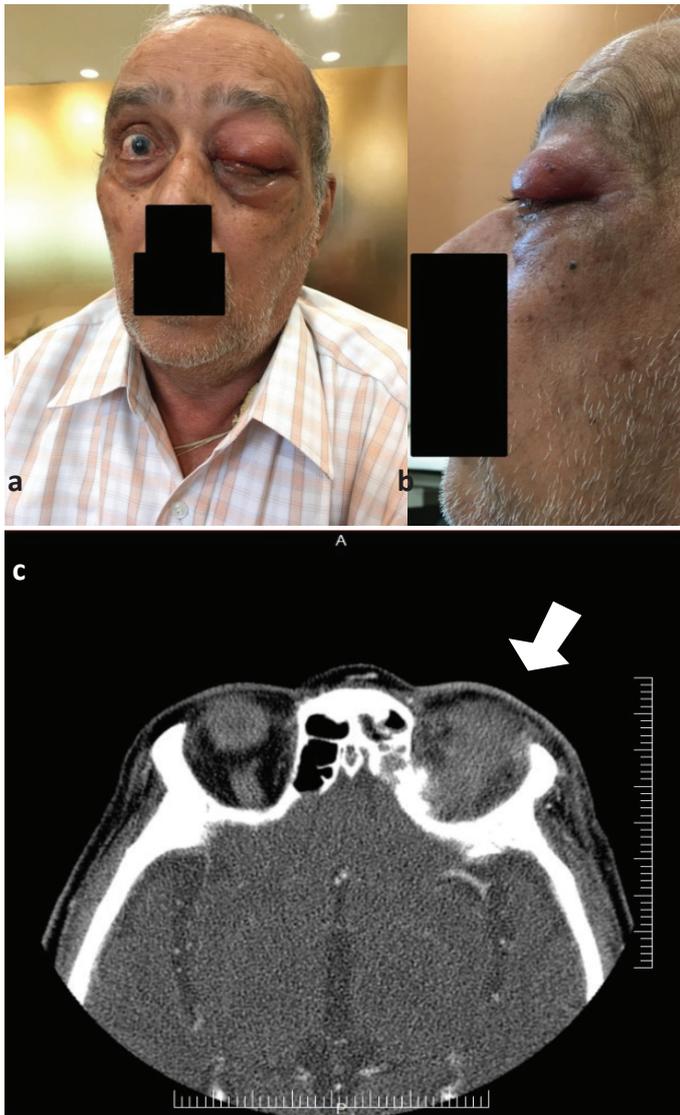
Clinical photographs depicting the proptosis (Figure a - anterior view and figure b - lateral view); axial section of CT brain depicting the soft tissue and lytic bony lesion in the left orbit (Figure c - white arrow).
